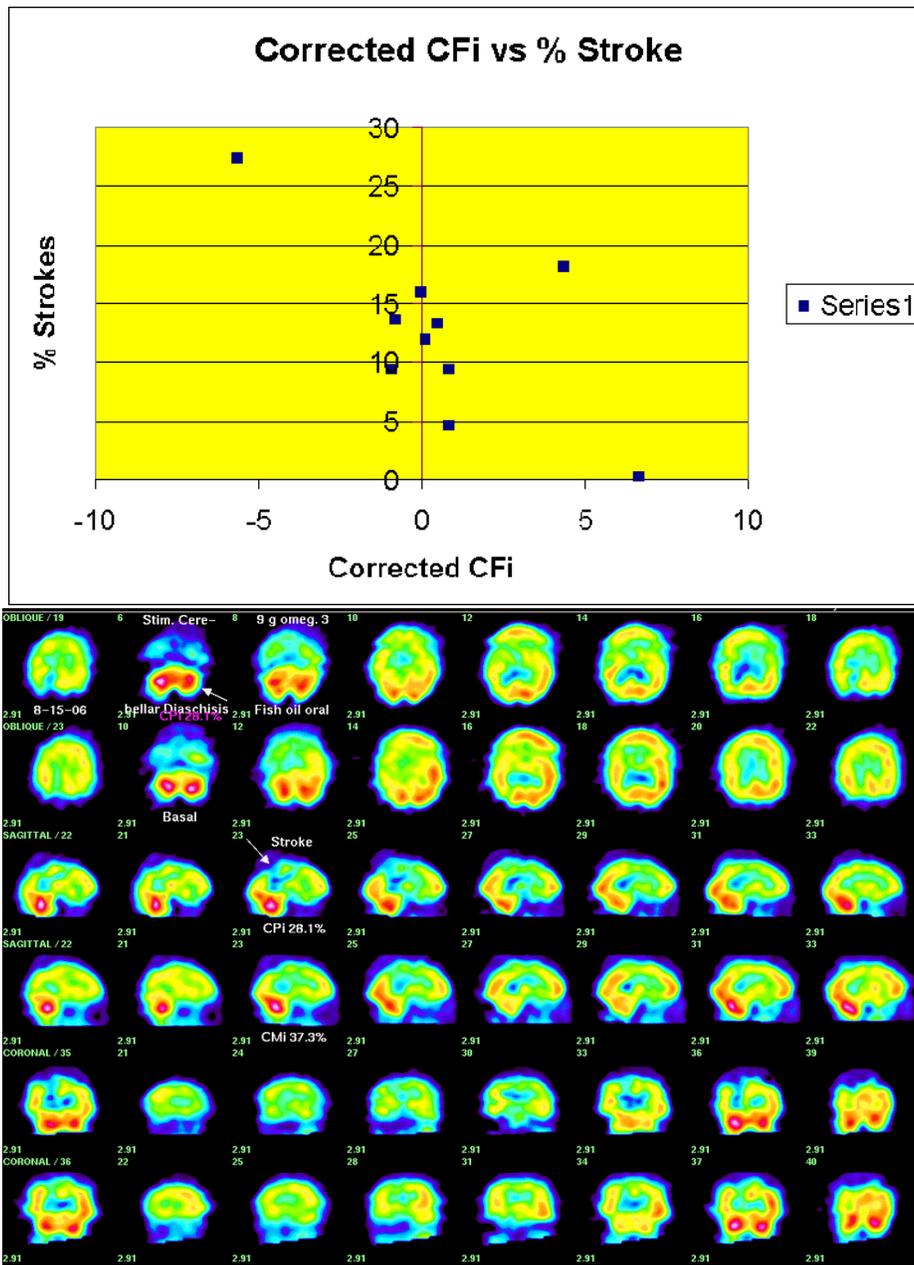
Below is SPECT for an 86 year-old woman with renal failure, serum creatinine 2.6 mg/dl, cystatin C 2.75 mg/L, and GFR 22 ml/min, exemplifies exception to the usual preservation of FRI with renal failure which is usually observed prior to stroke. The top row of each set of 3 paired images is post perfusion stimulation, using 10 g of fish oil in this case, which we have repeatedly shown is similar to either acetazolamide IV or nitroglycerin sublingual. A right posterior parietal stroke is easily appreciated. Saggital image 23 shows further decreased perfusion in the penumbra area as compared to the basal images below.
